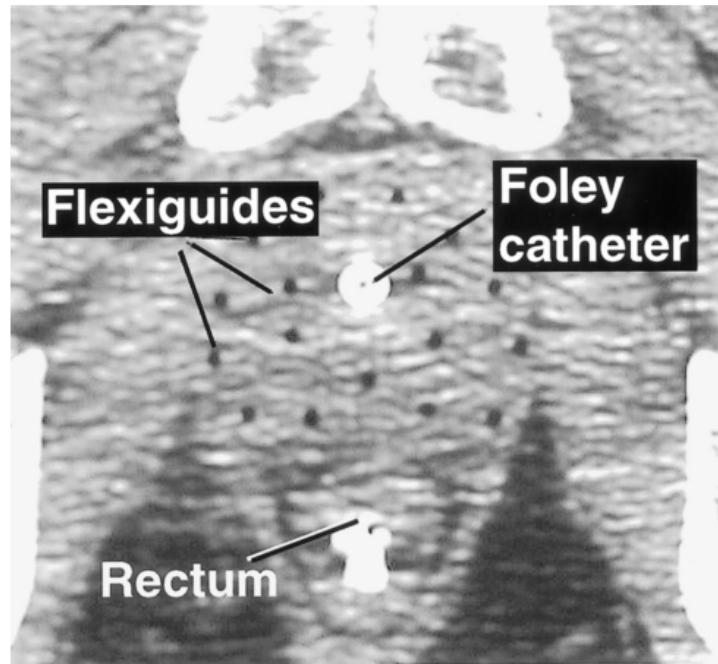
CT showing 17 flexiguides, urethra and rectal contrast. Note the position of catheter #15 is displaced posterior from central row to form the 'central' flexiguide in the posterior plane of the implant.
